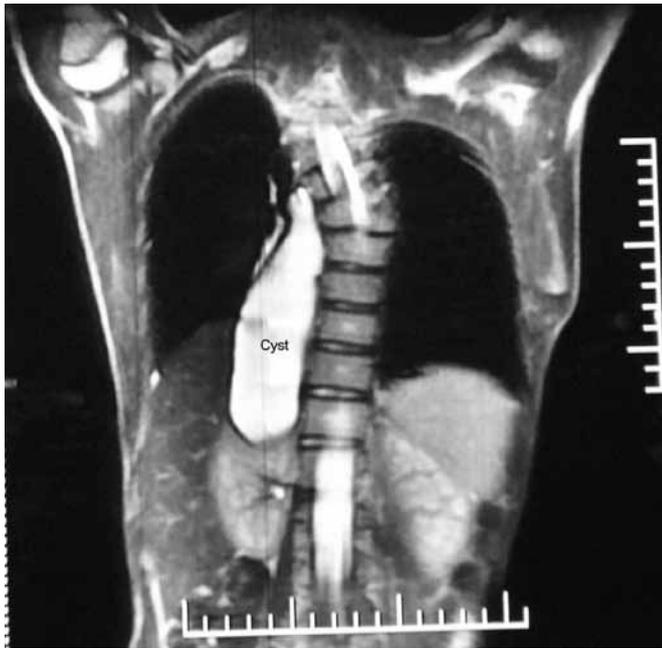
The entire lesion with thoracic and abdominal components (labelled 'cyst') seen in coronal sections of the MR images. Note the scoliosis and hemivertebrae. There is no demonstrable communication with the spinal canal.
